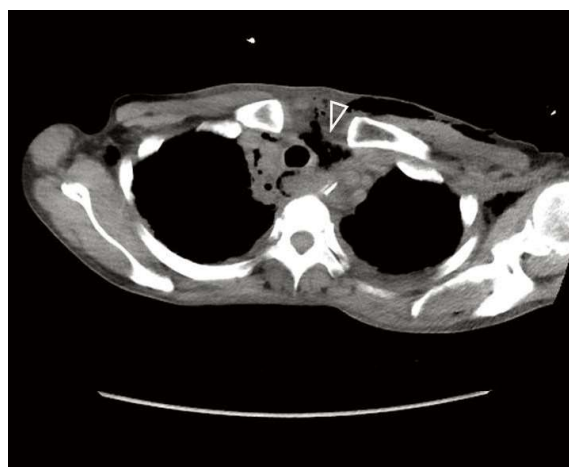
Chest computed tomography scan showing massive pneumomediastinum (hollow arrowhead).
